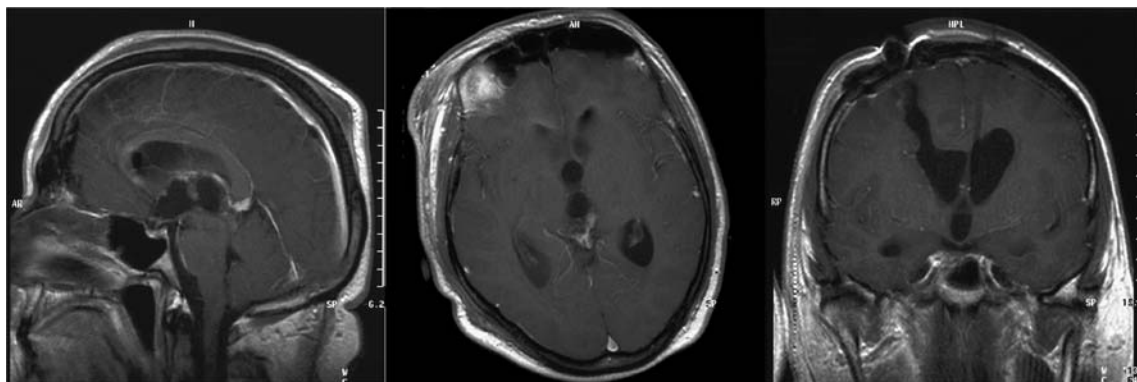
Early postoperative sagittal, axial, and coronal contrast-enhanced MRI scans
